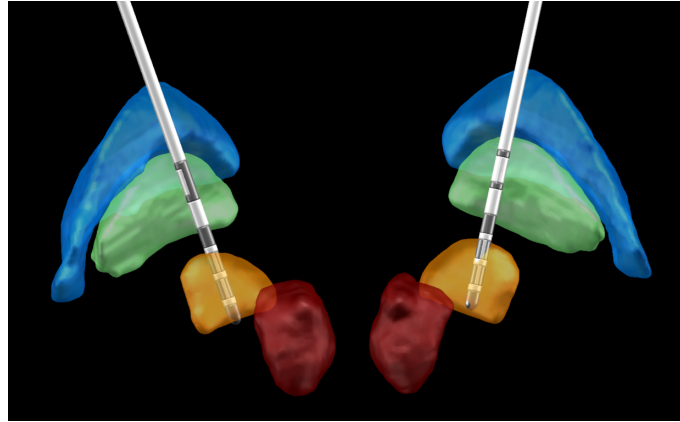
DBS leads localized in a patient MRI scan using Lead-DBS. Structures: red nucleus (red), STN (orange), GPi (green), GPe (blue).
